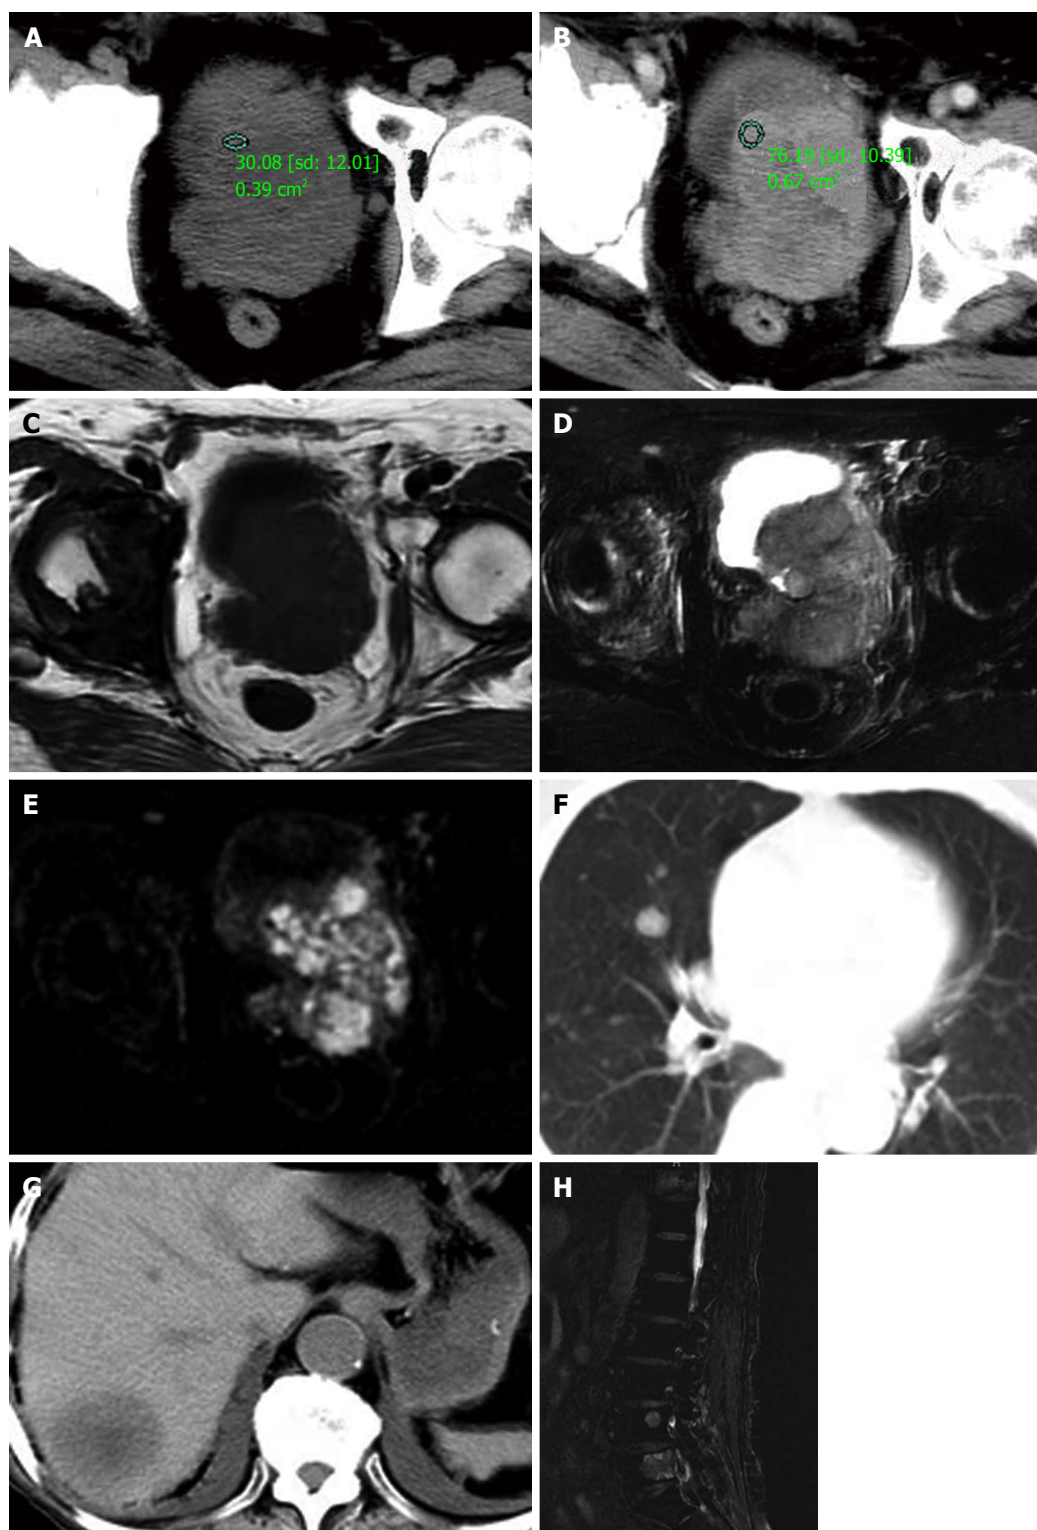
The diagnosis. Precontrast (A) and postcontrast (B) computed tomography (CT) images show the prostate approximately 6.5 cm × 7.5 cm × 7.2 cm in size with an irregular border and small necrosis in the center region, the solid part enhanced obviously in arterial phase of contrast enhancement CT scanning. T1-weighted image (T1WI, C) show the lesion to be slightly heterogeneous low signal intensity, T2WI (D), and diffusion-weighted image (E) show the same region to be heterogeneous hyperintense. Chest (F), abdominal (G) CT and lumbar (H) magnetic resonance imaging revealed multiple metastases to lungs, liver, and lumbar vertebrae.
